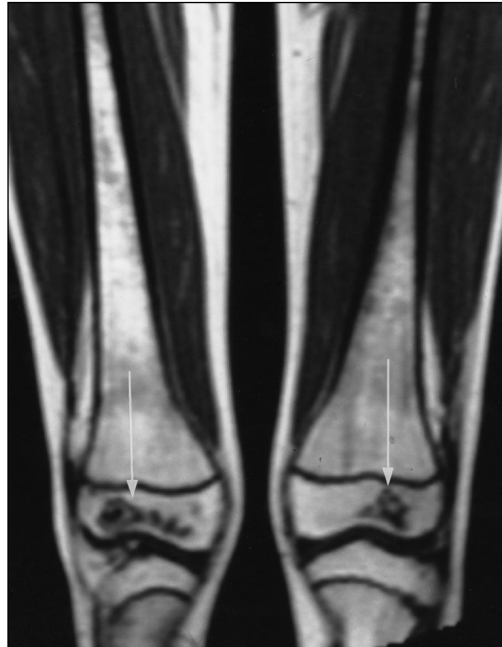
13-year-old girl who underwent chelation therapy for 7 years 7 months. Her height was at 10th percentile at time of MR imaging.
